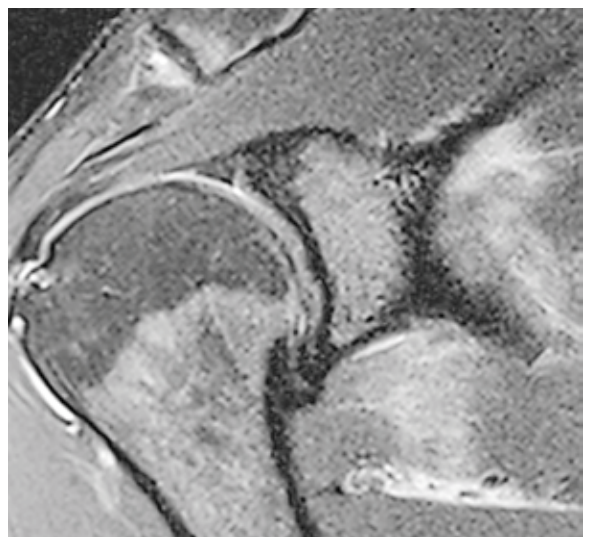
A stable fracture of the surgical neck of the scapula on MRI coronal scan.
